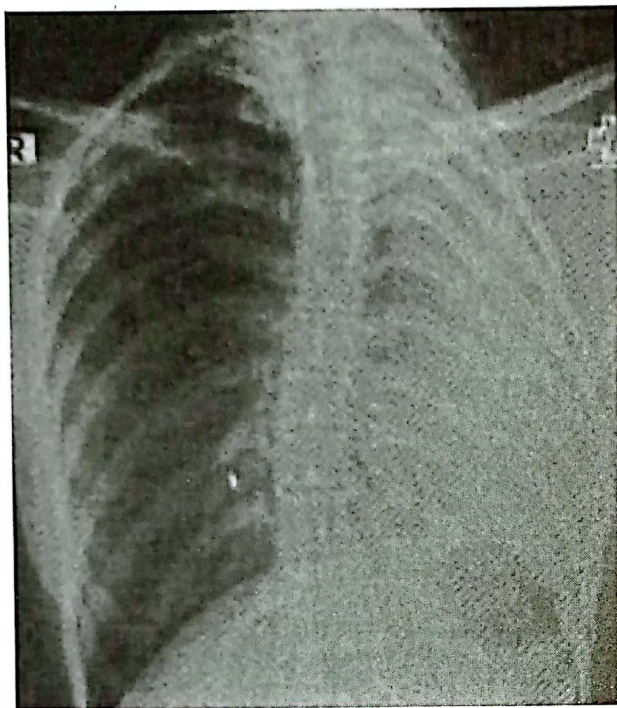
X-ray chest of a case of pulmonary agenesis showing homogenous opacification of left hemithorax associated with ribs crowding, elevation of left dome of diaphragm and pooling of the mediastinum and herniation of the compensatory emphysematous right lung.
